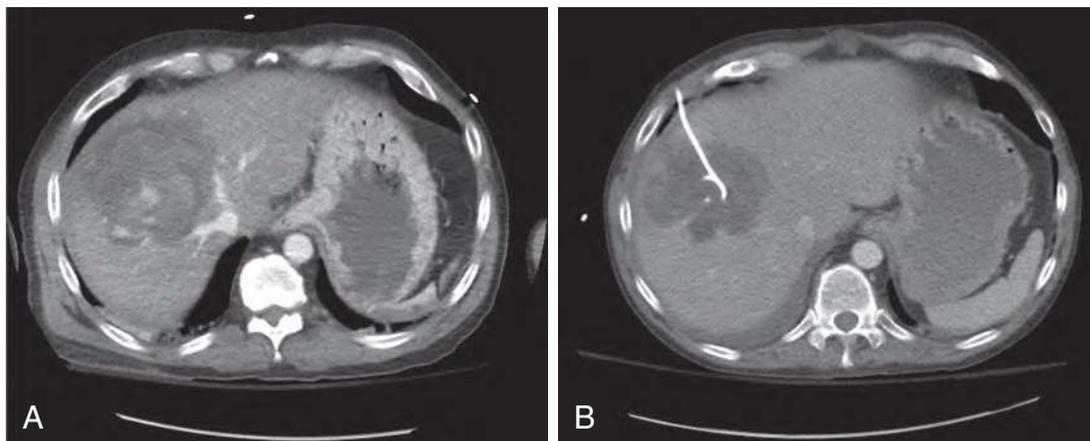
A 52-year-old-male, motor vehicle crash, hemodynamically normal. A, CT with contrast shows large active extravasation and clot in the right lobe of the liver. The right hepatic artery was embolized. The patient was managed nonoperatively and discharged from the hospital. B, The patient re-presented 2 weeks later with an elevated white blood cell count. A liver abscess was drained percutaneously.
